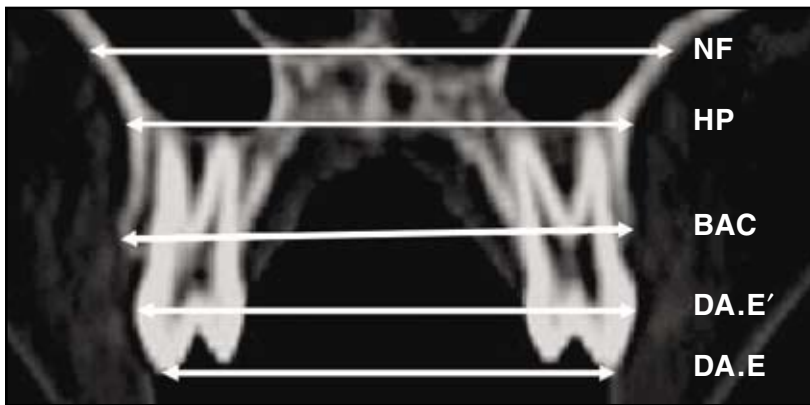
Measurement of external maxillary width. NF = maxillary width parallel to lower border of computed tomographic (CT) image and tangent to most superior level of nasal floor; HP = maxillary width parallel to lower border of CT image and tangent to hard palate; BAC = maxillary width at level of buccal alveolar crest; DA.E' = dental arch external width at most prominent area of buccal aspect of posterior teeth; DA.E = dental arch external width at level of buccal cusp tips.
